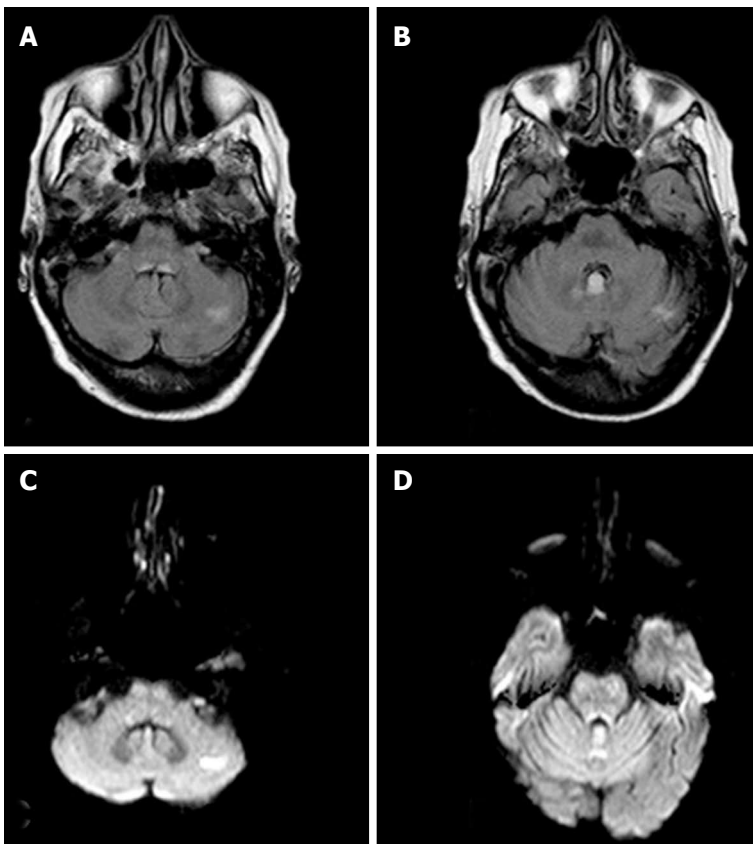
Magnetic resonance images in a patient with nonalcoholic Wernicke's encephalopathy. A: Axial FLAIR image shows a high signal intensity lesion in the left cerebellar hemisphere; B: Axial FLAIR image shows a high signal intensity lesion in the cerebellar vermis; C: Axial DWI shows a high signal intensity lesion in the left cerebellar hemisphere; D: Axial DWI shows a high signal intensity lesion in the cerebellar vermis. FLAIR: Fluid-attenuated inversion recovery; DWI: Diffusion-weighted imaging.
